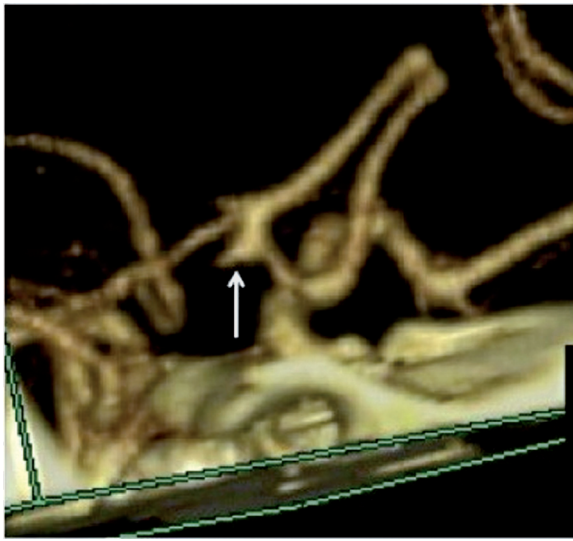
3D CT-angiography revealing what was thought to be an aneurysm originating from the right side of the ACoA adjacent to the R A1-A2 junction. There is complete occlusion of the right ICA and the right anterior circulation is supplied entirely by the left ICA.
